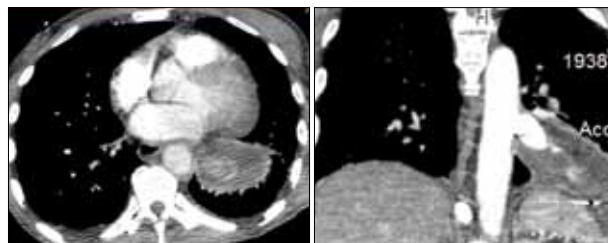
Thoracic computed tomography images acquired before surgery showing the pseudoaneurysm.
